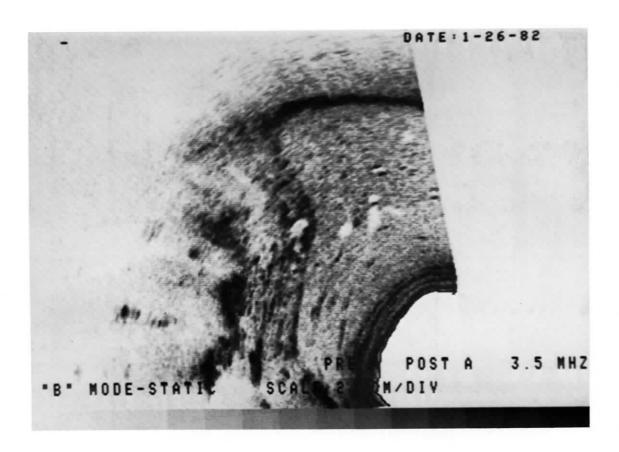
Ultrasound image produced with a video hard-copy camera.
